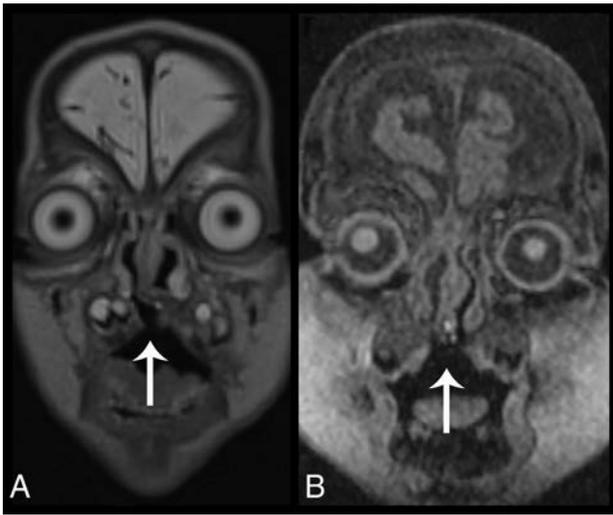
Cleft palate in 2 different patients. Coronal T2 SPACE reconstruction (A) and 3D T1-weighted coronal image (B) demonstrate a bony defect in the hard palate (arrows), allowing communication between the oral and nasal cavities.
